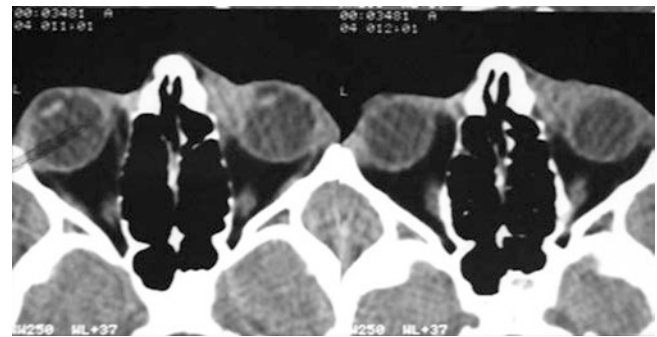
CT scan axial image showing left lacrimal sac enlargement with dacryolithiasis
